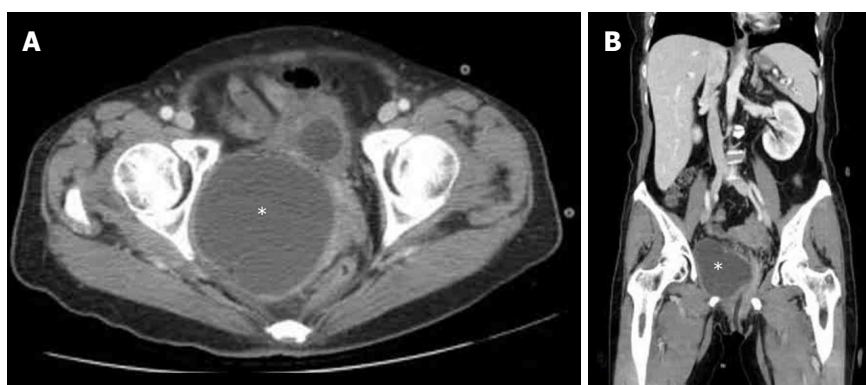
Pelvic computed tomography with axial (A) and sagittal (B) view showed a 9.1 cm cystic lesion (asterisks) with homogeneous content in right lower pelvic region.
